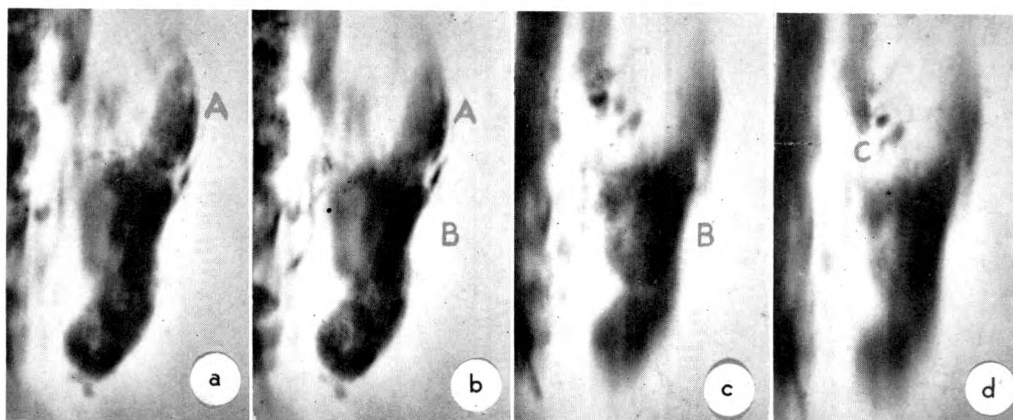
Case VI. Carcinoma of cervix uteri. (*a*, *b*, *c* and *d*) Tomograms showing that the apparently pathologic lymph node seen in Figure 15, *a* and *b* is composed of one oblong lymph node (A), one round lymph node, (B), and several spots of contrast medium (C). The lymph nodes here have a roentgenologically normal appearance.
